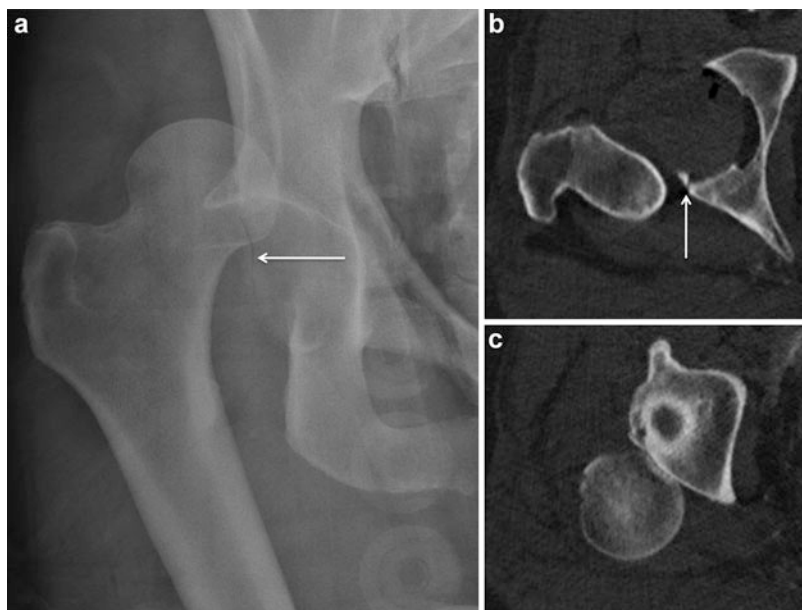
(a) AP radiograph of the right hip demonstrating a traumatic hip dislocation in the characteristic posterior and superior location. An *arrow* highlights the associated posterior acetabular wall fracture. (b) and (c) demonstrate axial CT images of the same hip demonstrating the dislocation and the associated posterior acetabular wall fracture. Because of the small size of the fracture fragment, the fracture was able to be treated non-operatively after concentric reduction of the hip
